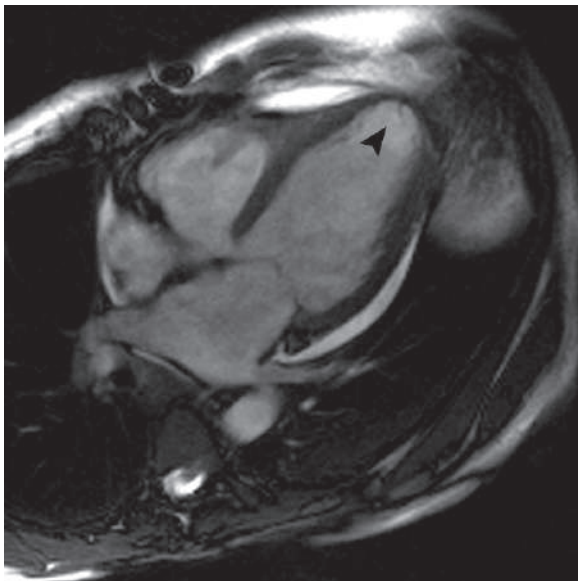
Four-chamber white-blood cardiac MRI shows left ventricular apical dilatation due to previous myocardial infarction (arrowhead)
